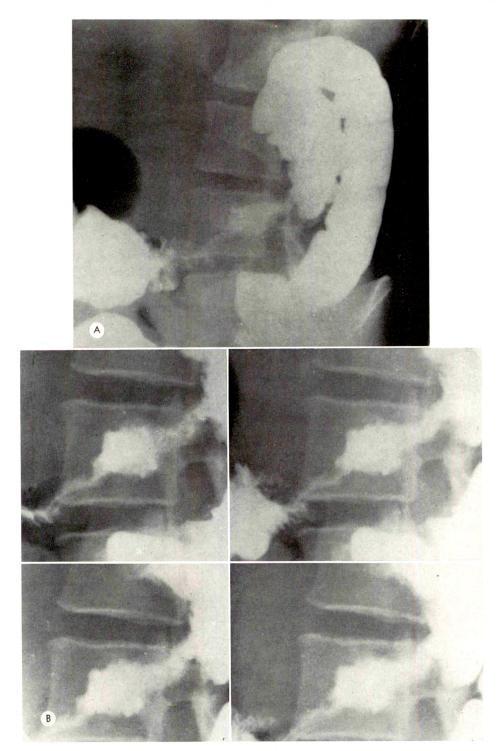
Case v. B. F., white female, 29 years old. Four month history of mass in left upper abdomen, anorexia and weight loss. At first operation it was thought to be carcinoma of the splenic flexure. Second surgery disclosed tumor in tail of pancreas invading the stomach and the transverse colon. (A) Extensive lesion, 3 inches long in left half of transverse colon near splenic flexure. Segmental fixation and mucosal destruction. (B) Spot roentgenograms of same lesion.
